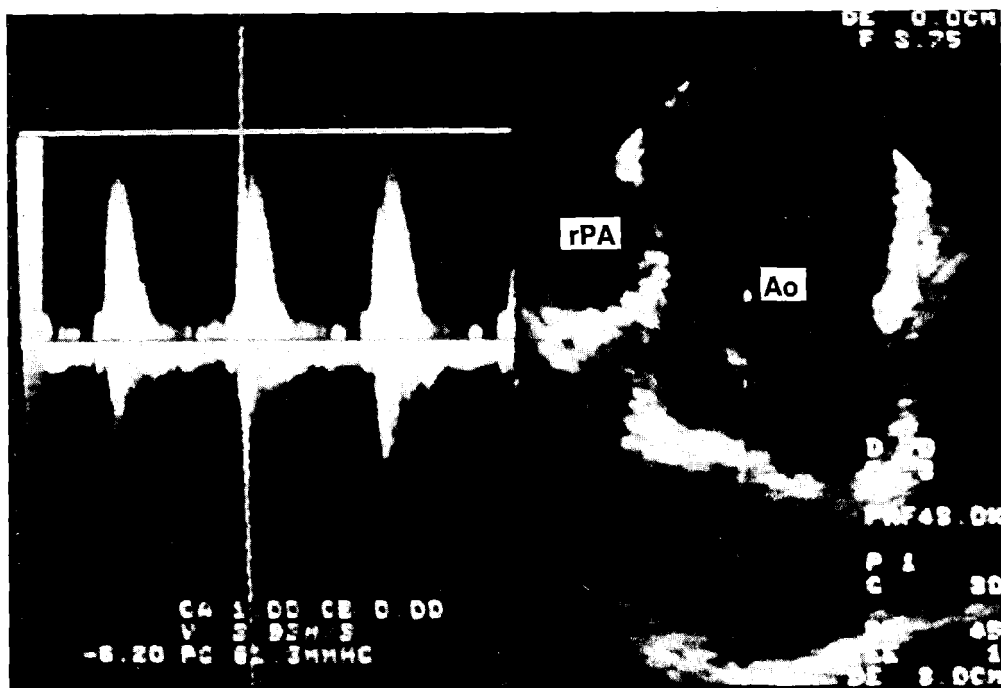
Epicardial assessment of the pressure gradient of a residual left ventricular outflow obstruction by placing the continuous wave Doppler probe on the ascending aorta and scanning downwards with the interrogating Doppler beam positioned through the aortic valve.
